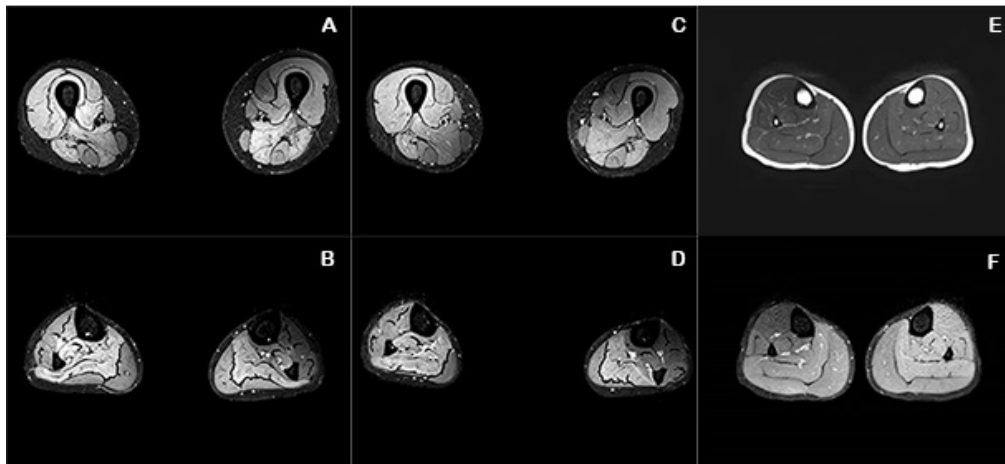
Muscle magnetic resonance imaging findings before and after riboflavin treatment. (A, B) Before treatment, the patient exhibited abnormal edema - like signals in both lower limbs; (C, D) After one - month treatment, these signals had not significantly changed; (E, F) A year later, the bilateral calf muscle edema became less obvious.
